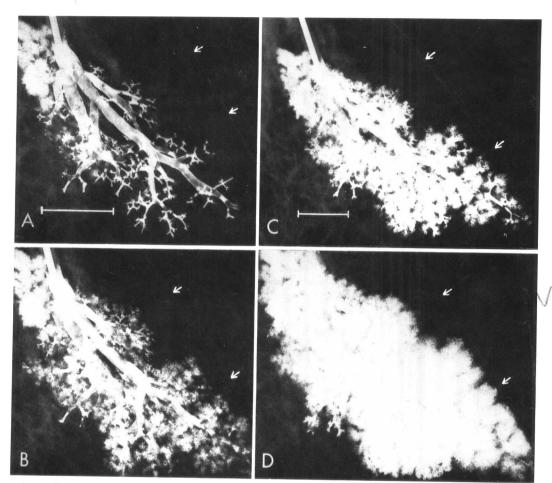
Roentgenograms showing progressive opacification by tantalum dust of a segment of a human bronchial tree distal to a wedged catheter. Initially, A, mainly nonrespiratory bronchioles are visible with some early filling of acini, producing stippling and rosettes. After further opacification, B to D, the mosaic of more spherical, superimposed but distinct acini is visible. *Arrows* indicate the pleural surface. Marker in A represents 2.2 cm in A, B and D; that in C represents 1.8 cm. (From Gamsu, G., *et al.*: Invest. Radiol. 6:171, 1971.)
